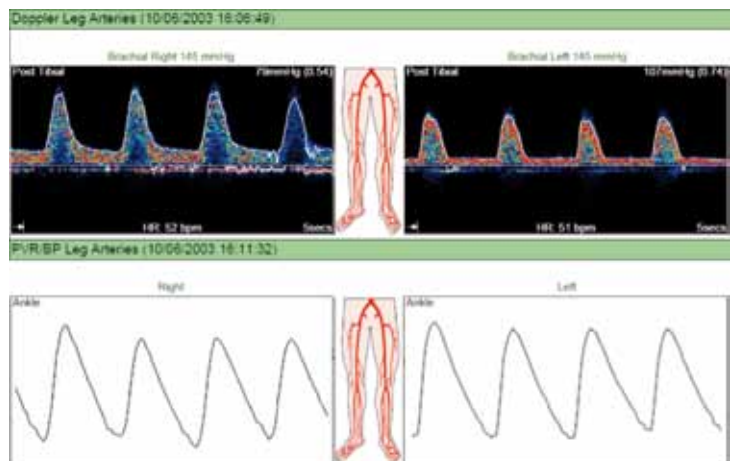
Both legs have moderate PAD with monophasic Doppler waveforms, low pressures and ABIs and abnormal PVR's (grade B-C).
